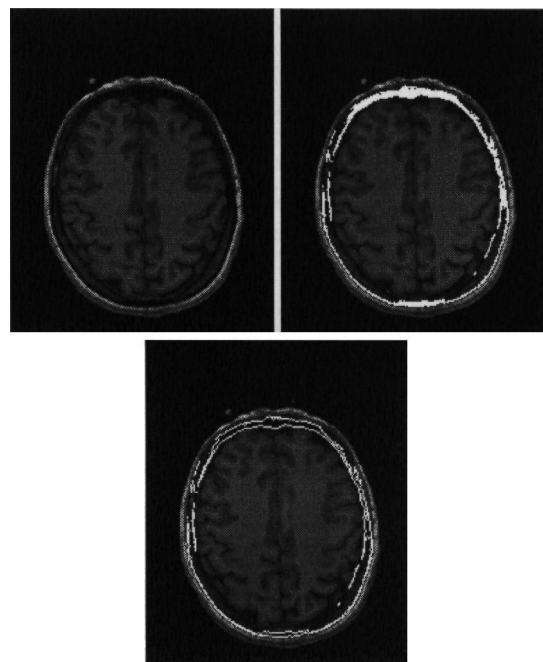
Pre-segmentation of the skull: a slice of the MRI volume (top left). Result of the region growing (top right) with  $s_{\text{inf}} = 20$ . The contour of the pre-segmented region taken as an initialization of the deformable model (bottom). Obtained statistics are:  $\mu_{\text{bone}} = 8.40$  and  $\sigma_{\text{bone}} = 6.02$ .
